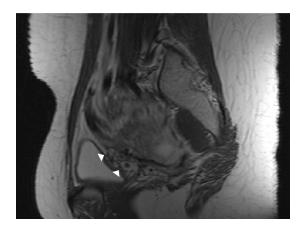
Sagittal section on magnetic resonance imaging demonstrating loss of integrity of the lower uterine segment with invasion of placental tissue (arrow heads).
